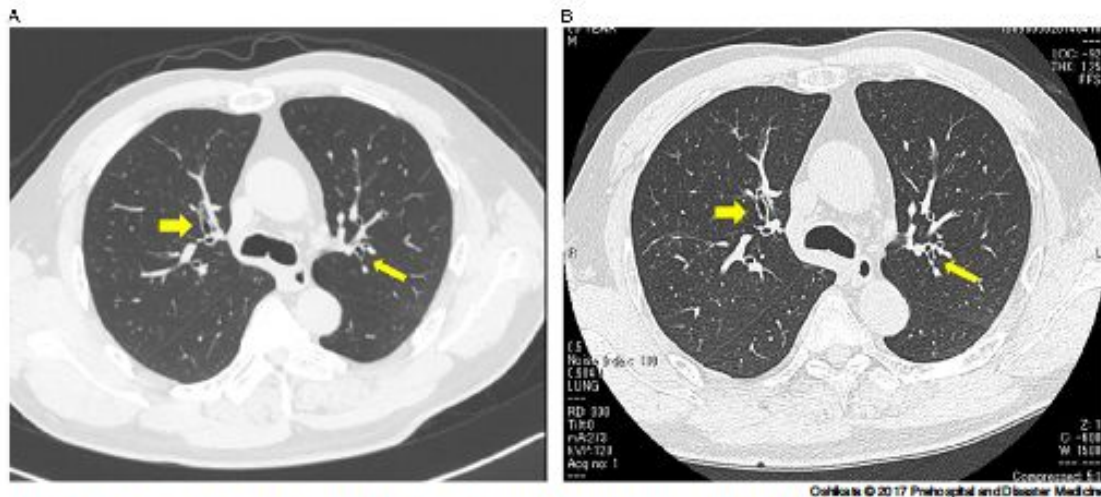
Computed Tomography Scan of the Upper Lungs of Patient, Performed in A: August 2013 and B: April 2014. Note: Central bronchiectasis in right B3 and in left B2 (arrows) was more prominent in April 2014 than in August 2013, and bronchial wall thickness was greater in April 2014 than in August 2013.
